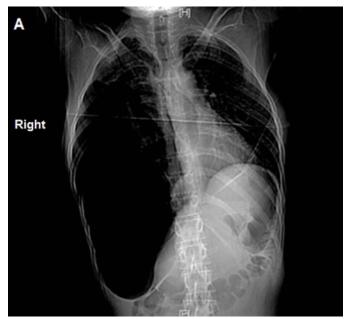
Anteroposterior chest radiograph showing a large collection of gas in the right hemithorax with inversion of the right hemidiaphragm.
